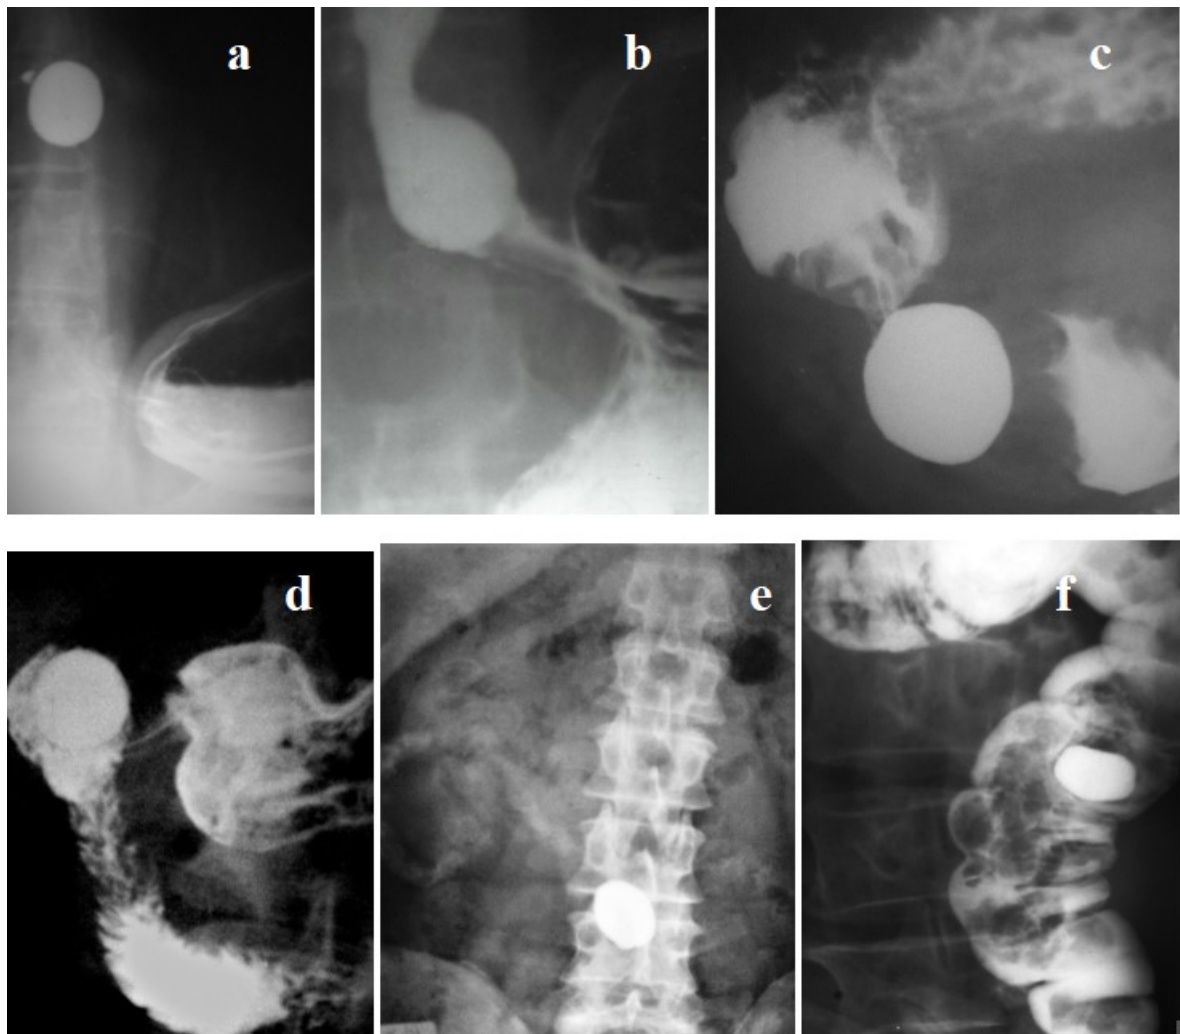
Radiographs of different patients who swallowed LT. (a) BT in the middle of the esophagus; (b) above the contracted lower esophageal sphincter; (c) in the antrum of the stomach during antral systole; (d) in the duodenal bulb; (e) an x-ray was taken 28 hours after swallowing the last LT. A reduced tablet is visible at the level L 3-4. Traces of barium from the disintegrated surface layer of the tablet are visible in the loops of the small intestine; (f) in the sigmoid colon.
